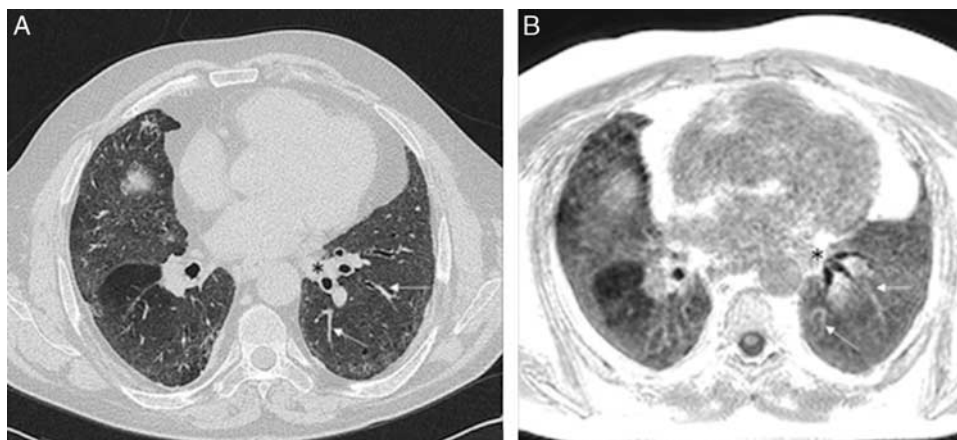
CT and UTE sQA SSc-ILD extent analysis. ILD was scored as 85% total lung parenchyma at level 5 on both CT (A) and UTE (B). Breath-hold CT and free-breathing UTE acquisitions may lead to slightly anatomical differences at the same level, as it was shown by left lower lobe bronchi (black asterisks); however, visualized segmental vessels are the same (white arrows).
